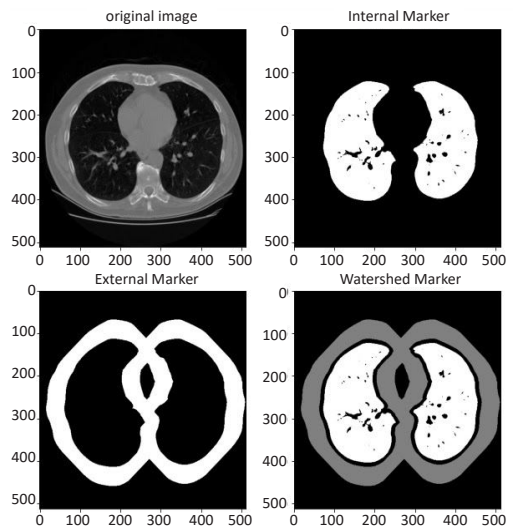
Distinct markers are derived from the watershed algorithm applied to the CT scan
